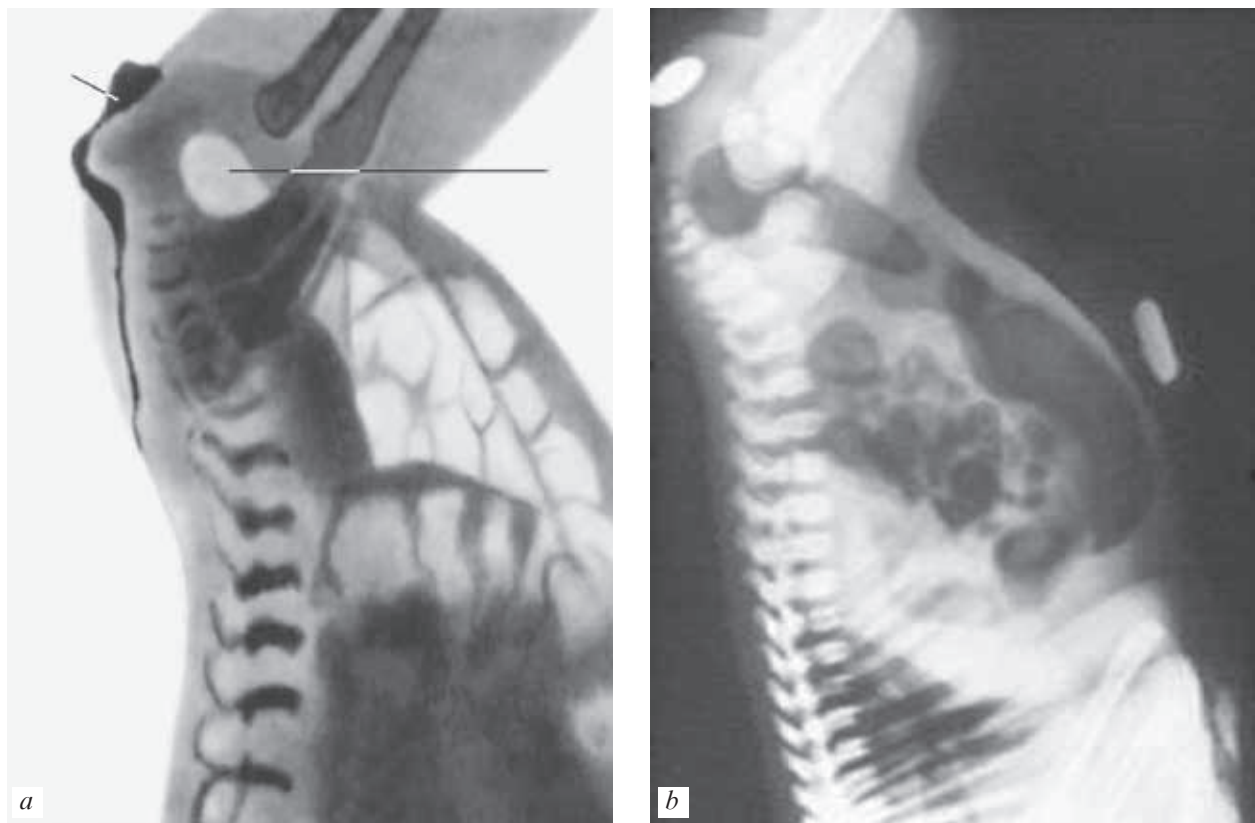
X-ray examination in atresia of the rectum (after Wangenstein) (a, b)
